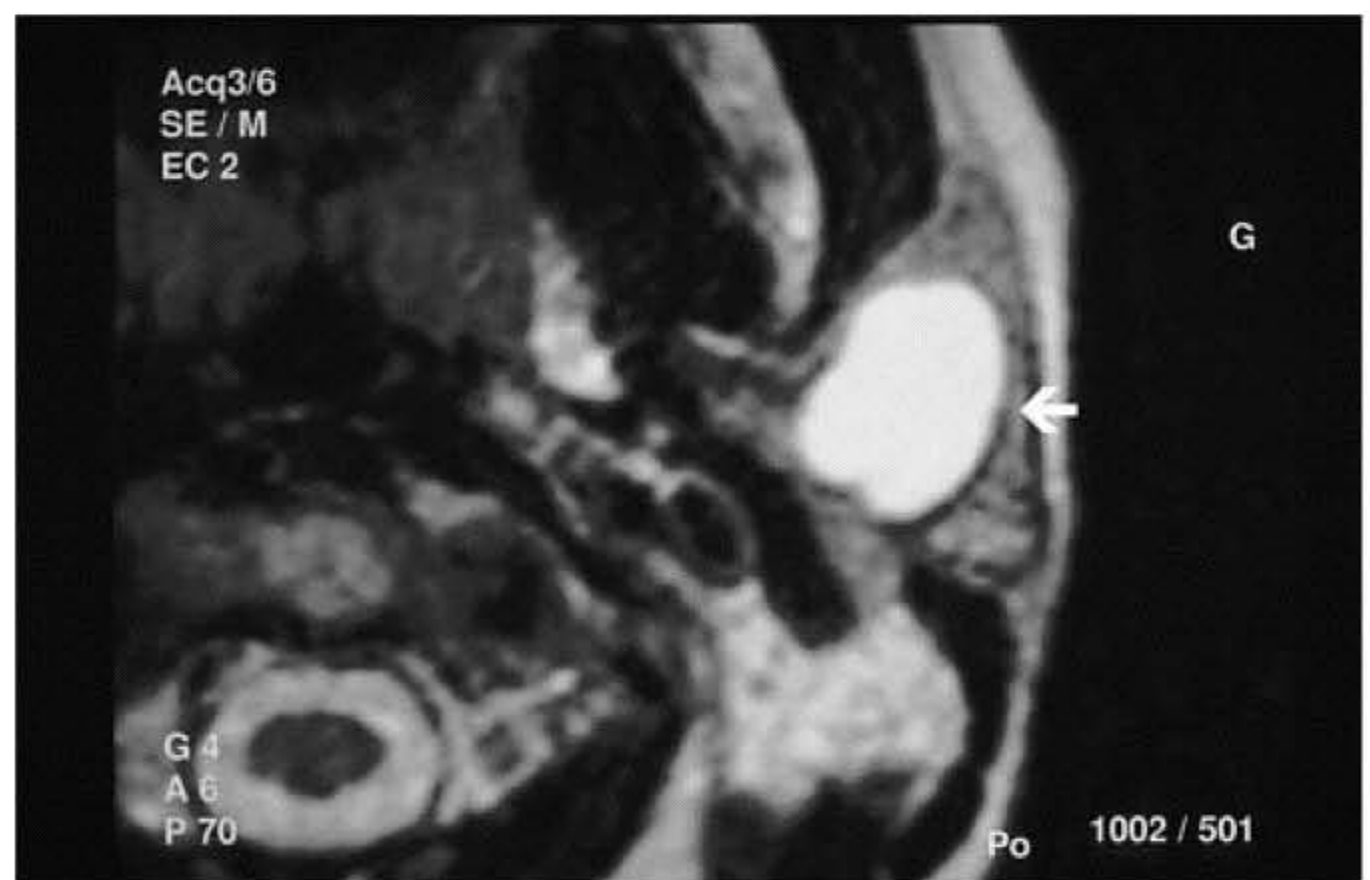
Large left intraparotid cyst (arrow) with a high-intensity signal on axial T2-weighted MRI.
